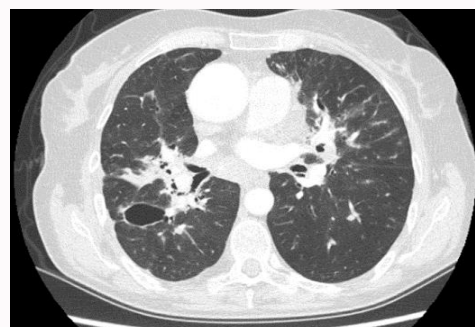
Thorax CT revealing stage III sarcoidosis with a cystic lesion and fibrotic parenchymal changes.
